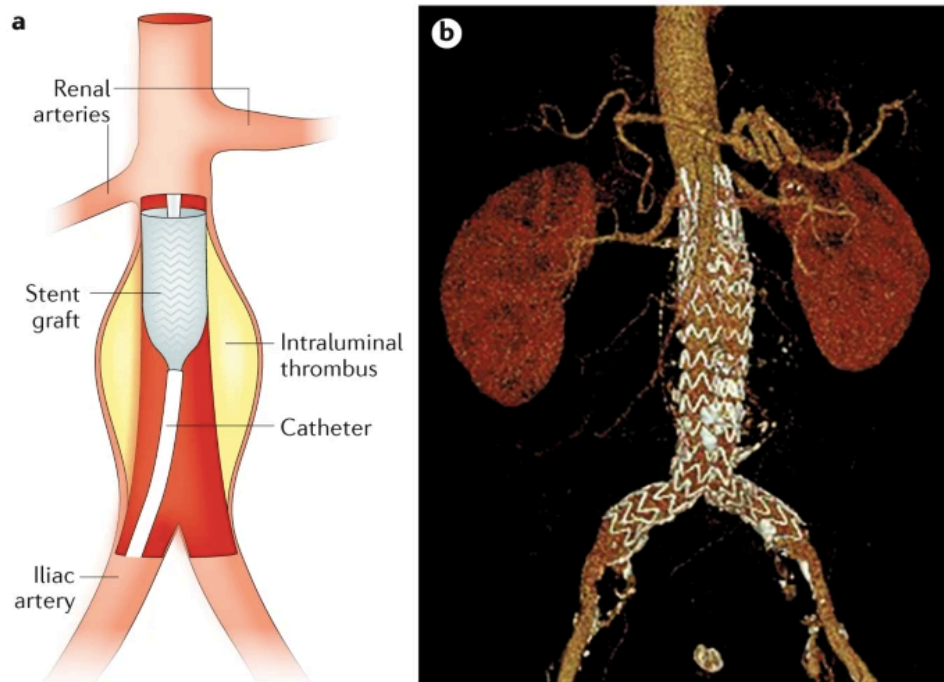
a) Deployment of graft. The top section of the stent graft is deployed, revealing the proximal part of the stent graft within the aorta beneath the renal arteries, effectively sealing the neck proximally to the aneurysm. b) CT image of the EVAR stent graft showing two extended grafts continuing into the common iliac arteries. (139)
